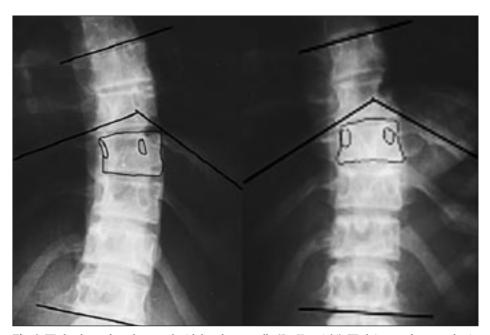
Wedged vertebra, derotated with hand - manually (Dr. Kotwicki). Wedging can be seen also in the derotated spine, and its size is just a little different from the previous view. Both radiographs have been made a couple of seconds from one to another.
